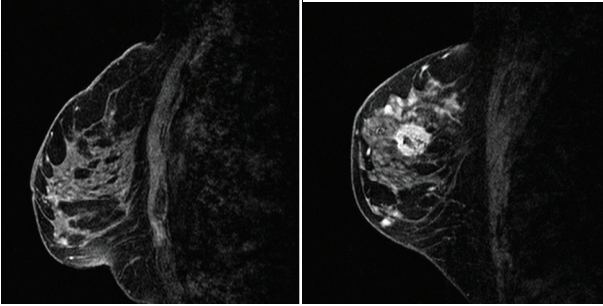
3D dynamic bilateral fat-saturated breast MRI (Turbo Harmony): 1 pre-contrast followed by 5 post-contrast acquisitions at 1 minute increments. Note the good bilateral fat-saturation. The infiltrating ductal cancer enhances quickly (1 min) with a wash-out (signal decrease over time).
